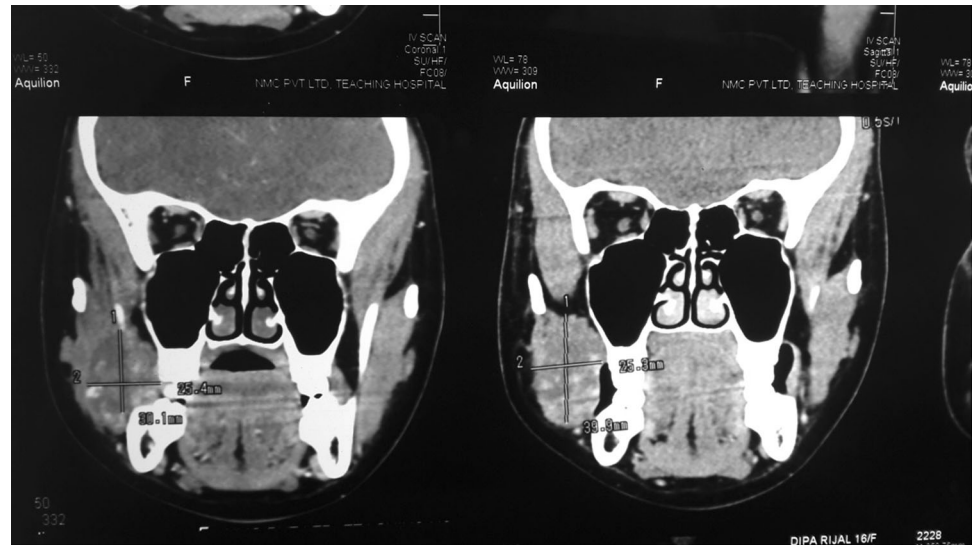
CT scan of the patient (Axial cuts)
